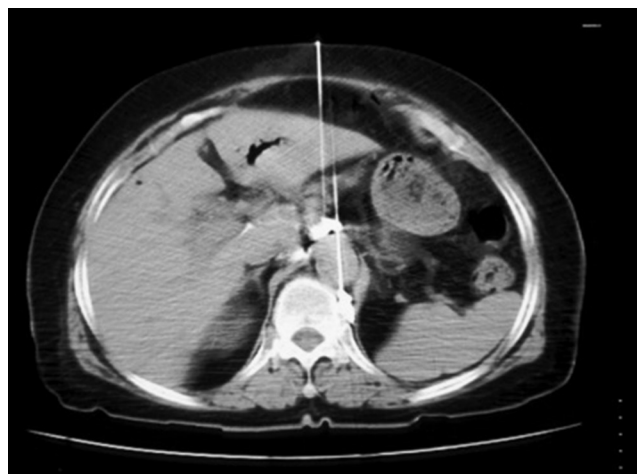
Computed tomography section demonstrating a transhepatic transaortic approach to the placement of the left splanchnic needle with contrast demonstrating satisfactory distribution in the left retrocrural space. The single celiac needle is also in good position
